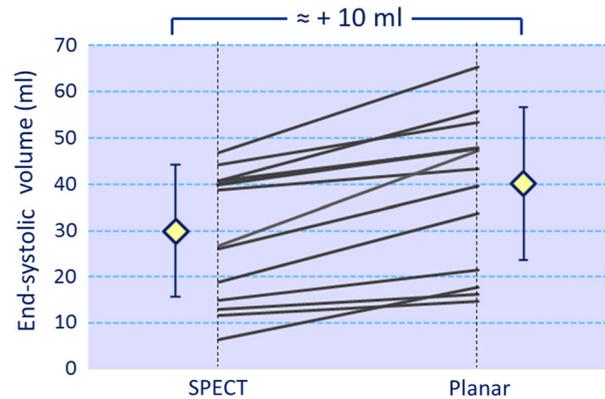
Comparison of the end-systolic volumes calculated with the EF from planar- (left) or SPECT images (right) in twelve presumably normal patients, yielding evidence of an averaged volume shift of almost 10 mL between the 2 techniques (see methodological details in the text).
